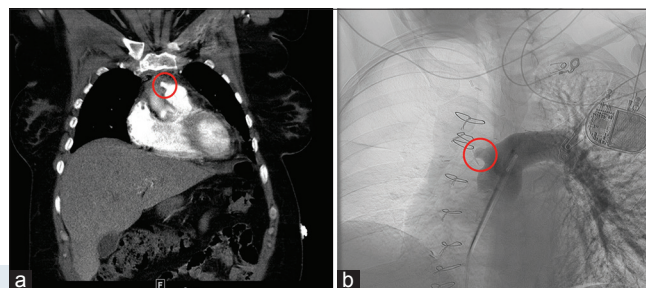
A 41-year-old female with anomalous aortic origin of the left coronary artery, status post-mobilization of the anomalous left main coronary artery, pulmonary artery translocation, and interposition of a 16 mm Dacron graft to the right pulmonary artery who presented with chest pain and shortness of breath. (a) Coronal image from a contrast-enhanced computed tomography of the chest demonstrating the main pulmonary artery and truncated the right pulmonary artery graft (circle). (b) Day 0: Pulmonary artery angiogram opacifying the native left pulmonary artery and truncated the right pulmonary artery graft (circle).
